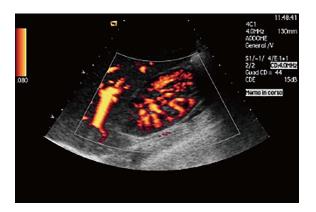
Case 2: Abdominal ultrasound. Abdominal ultrasonography with power-doppler analysis shows two hypoperfused areas at the upper pole of right kidney.
